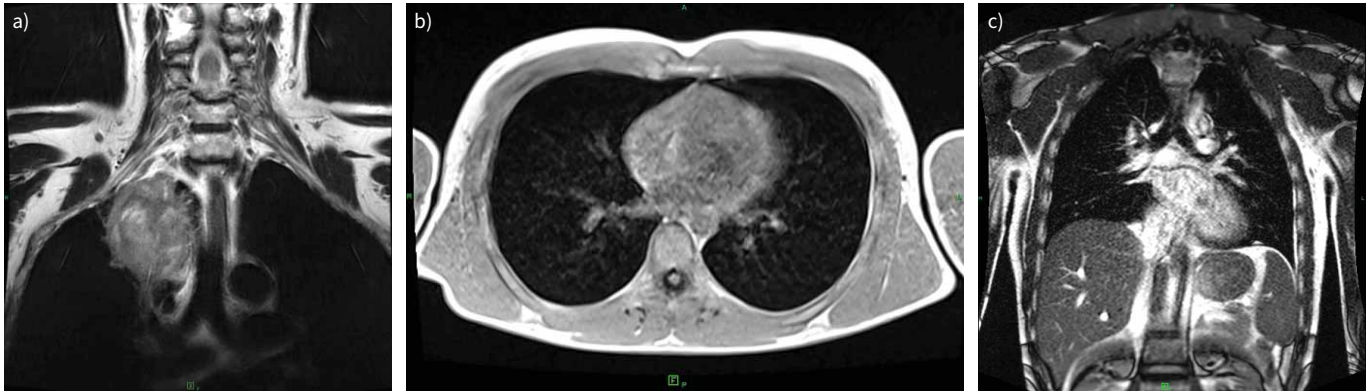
Magnetic resonance imaging (MRI). a) Axi T2 PROPELLER MRI scan of a 68-year-old patient demonstrated right upper lobe Pancoast tumour, with infiltration of the adjacent soft tissues. The tumour appears to be separated from the superior vena cava and the right brachiocephalic vein, as well as from the brachial plexus, by a narrow band of fat, while infiltration of the right subclavian artery has arisen. b and c) Low-field (0.55 T) MRI study of the lung with b) axial T1 VIBE TRA and c) coronal T2 TRUFI P2 FS sequence for the study of diaphragmatic motion during free breathing.
